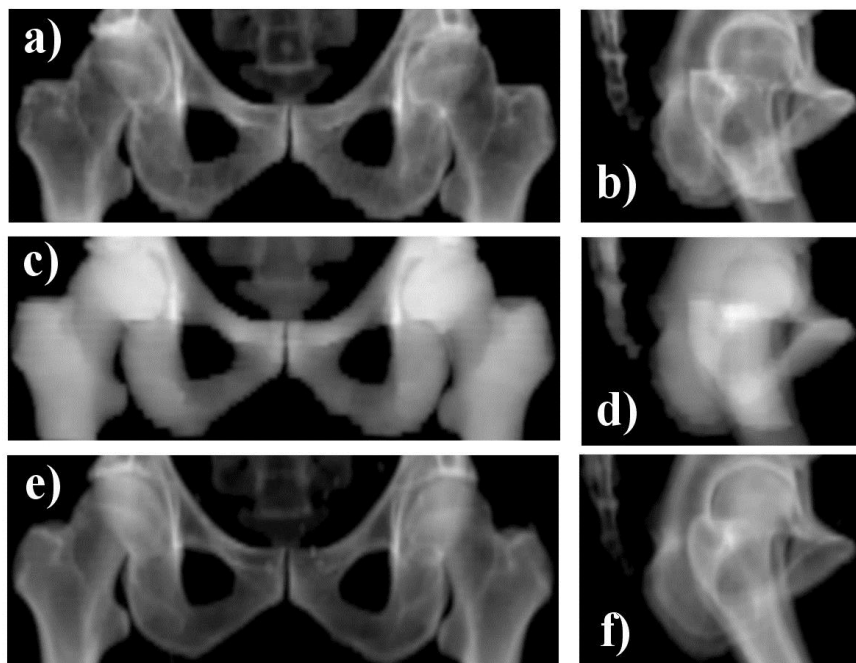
Example reference DRRs reconstructed from different 3D image series: the heterogeneous pseudo-DRRs (a) & (b), the bulk pseudo-DRRs (c) & (d), and the CT-DRRs (e) & (f) (PA & RL, respectively).
